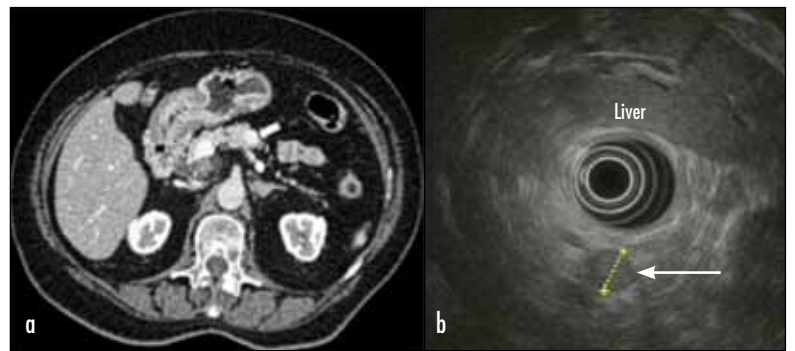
Neuroendocrine tumour: patient with previous pancreatitis under investigation for cyst within uncinate process of pancreas identified with transabdominal ultrasound. a. Axial computed tomography performed in the arterial phase also demonstrates a well-demarcated hypervascular lesion measuring 10 mm in the pancreatic body (arrow). b. Radial endoscopic ultrasound demonstrates a 10 mm hypoechoic lesion with distinct margins in the pancreatic body (arrow).
